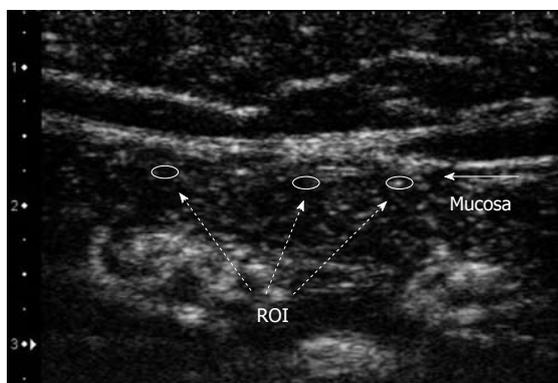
Image of contrast-enhanced ultrasonography. Regions of interests (ROI) were placed in the mucosal area of the small bowel at three regions. A time intensity curve of blood flow enhancement signal was plotted from recorded ultrasonographic images.
